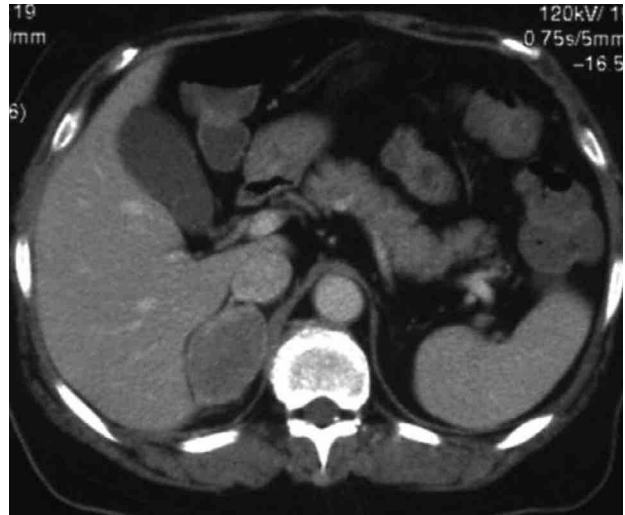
CT showing rapid enlargement of the metastatic adrenal tumor, reaching 57 mm in diameter 15 months postoperatively.
